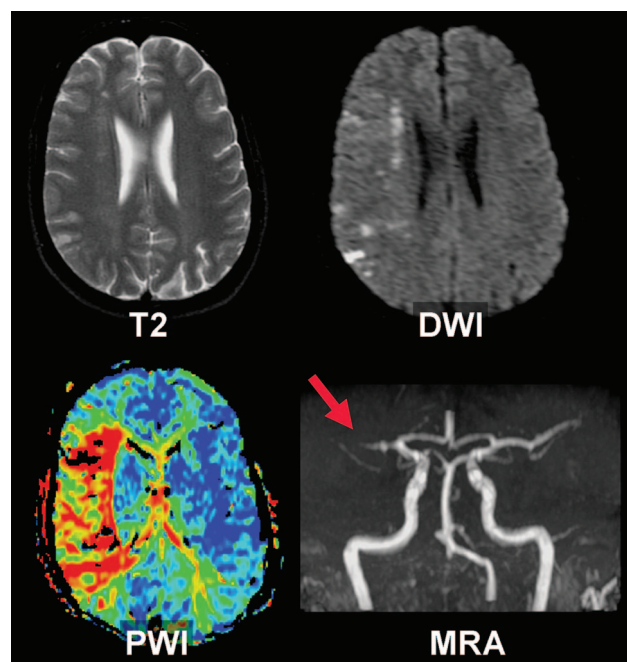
Acute right middle cerebral artery occlusion and ischemia. Noncontrast 3-dimensional time-of-flight MRA shows no flow beyond the M1 segment of the middle cerebral artery (arrow). There are early ischemic changes in a small portion of the right hemisphere on diffusion-weighted images (DWI) and a larger area of impaired perfusion on perfusion-weighted images (PWI; first moment transit time). Such a PWI–DWI mismatch may help define a target for emergent revascularization.
